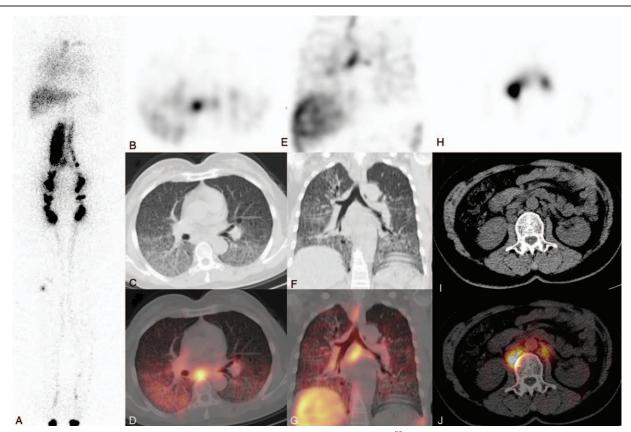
Representative images of lymphangioleiomyomatosis in patient 8. (A) Anterior image of ^{99m}Tc-ASC lymphoscintigraphy after 1-h injection; (B–D) axial SPECT, CT, and fusion images of chest; (E–G) coronary SPECT, CT, and fusion images of chest; H-J, axial SPECT, CT, and fusion images of the abdomen.
